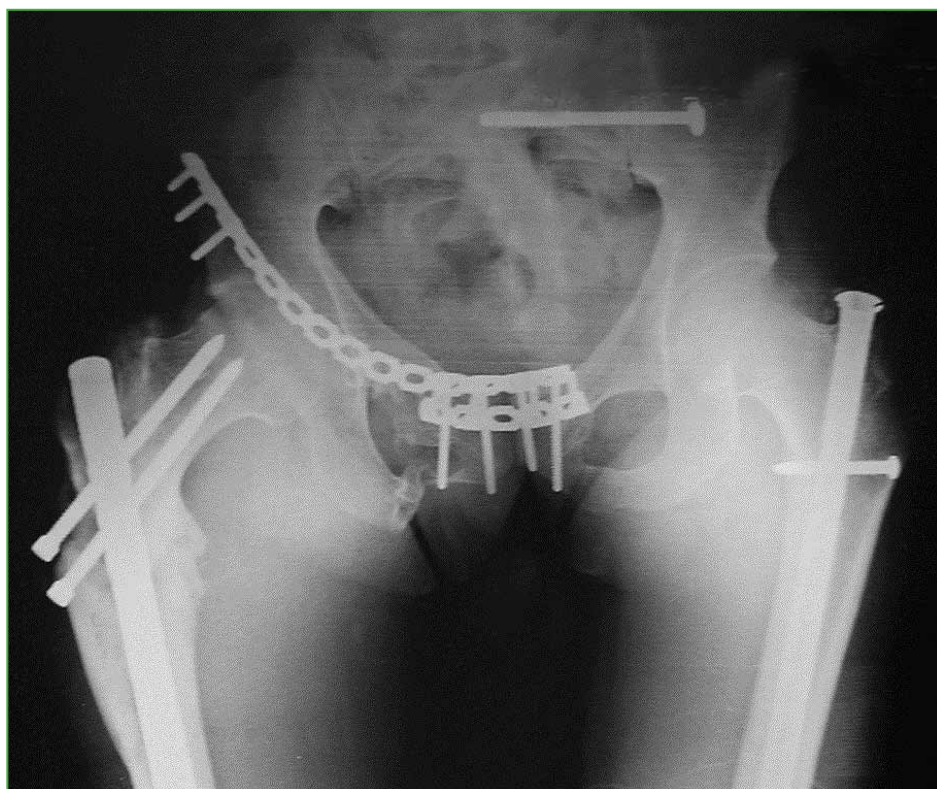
Pelvic radiograph including proximal femur. Postoperative control of a patient with floating hip and osteosynthesis of the pelvis and bilateral femur.
